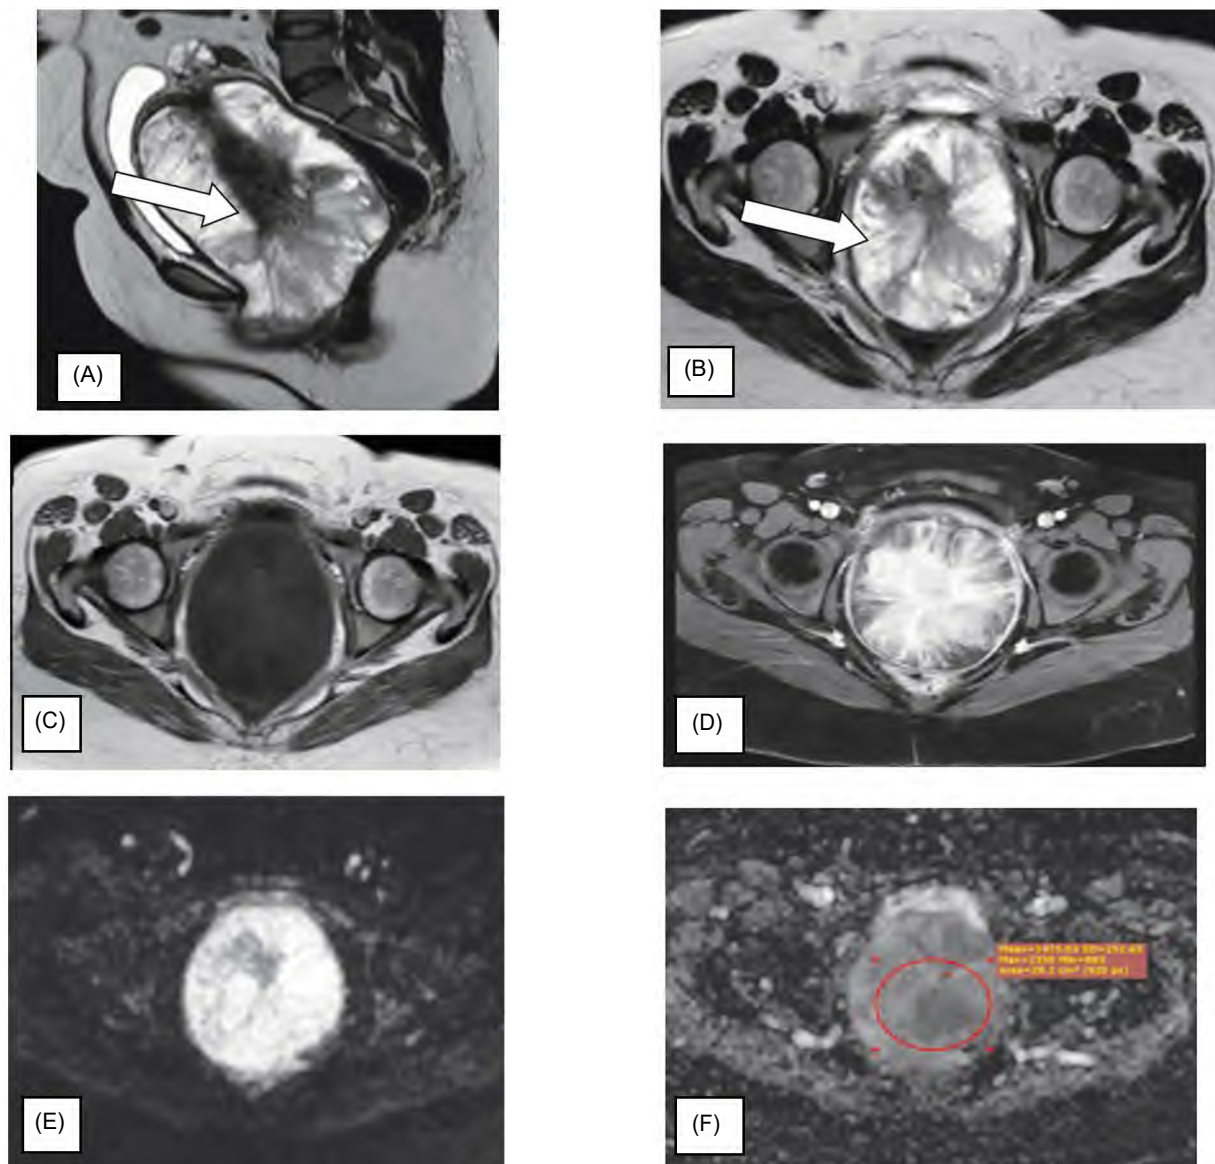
A 32-year-old female presented with vaginal mass and pain. Sagittal T2WI. (A) Axial T2WI. (B) and axial T1WI. (C) Showing huge vaginal mass distending the vagina and vaginal fornices eliciting low heterogeneous signal in T1WIs and high heterogeneous signal in T2WIs. The mass is seen stretching the urinary bladder and rectum with no extra vaginal extension. Post-contrast. (D) It shows heterogeneous enhancement with a swirled pattern. DWI and ADC image. (E,F) The lesion shows a high signal on DWI and a low signal on the corresponding ADC maps. ADC value was $(1.4 \times 10^{-3} \text{ mm}^2/\text{s})$. It was proven vaginal angiomyxoma.
